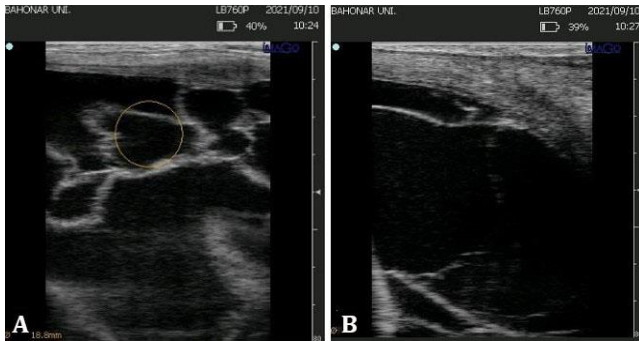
Ultrasound image of the mare uterus in rectal palpation. A) Irregular lines in a fluid-filled space (yellow circle) representing membranes floating in the intra-uterine fluids are evident. B) There is no trace of the attachment of the placenta to the endometrium near to external os of cervix. It seems that these membranes have some connections with the inner surface of the uterus.
